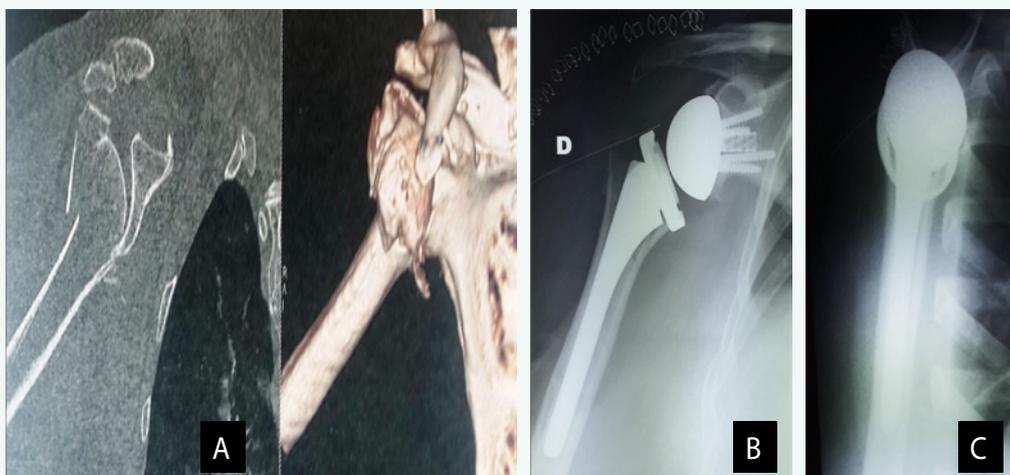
Case of comminuted fracture. (A) Computed tomography of the right shoulder showing a comminuted fracture; (B and C) X-ray control after inverted total shoulder arthroplasty.
